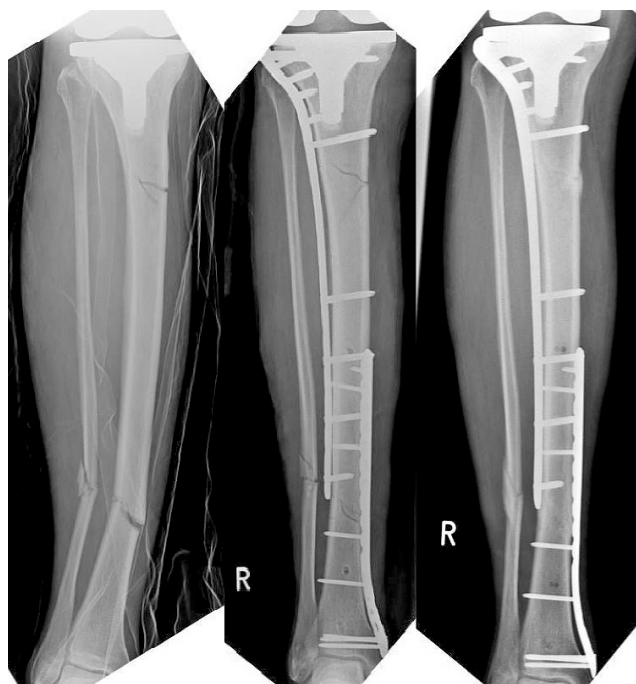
Type IIIA tibial fracture treated by MIPO plating (L.I.S.S. and low bend tibia LCP, Synthes), trauma x-ray (left), postop x-ray (middle), bony healing 11 weeks after operation (right).
